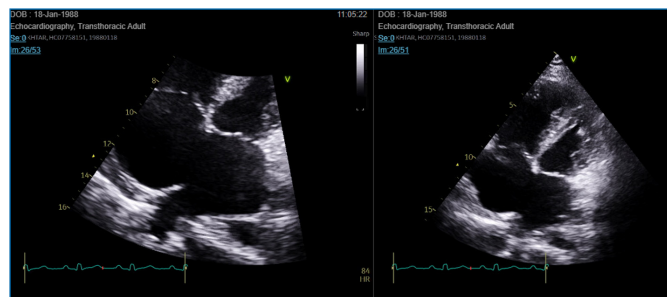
Echocardiographic evidence of secundum type atrial septal defect at apical four-chamber views with significantly dilated right chambers
